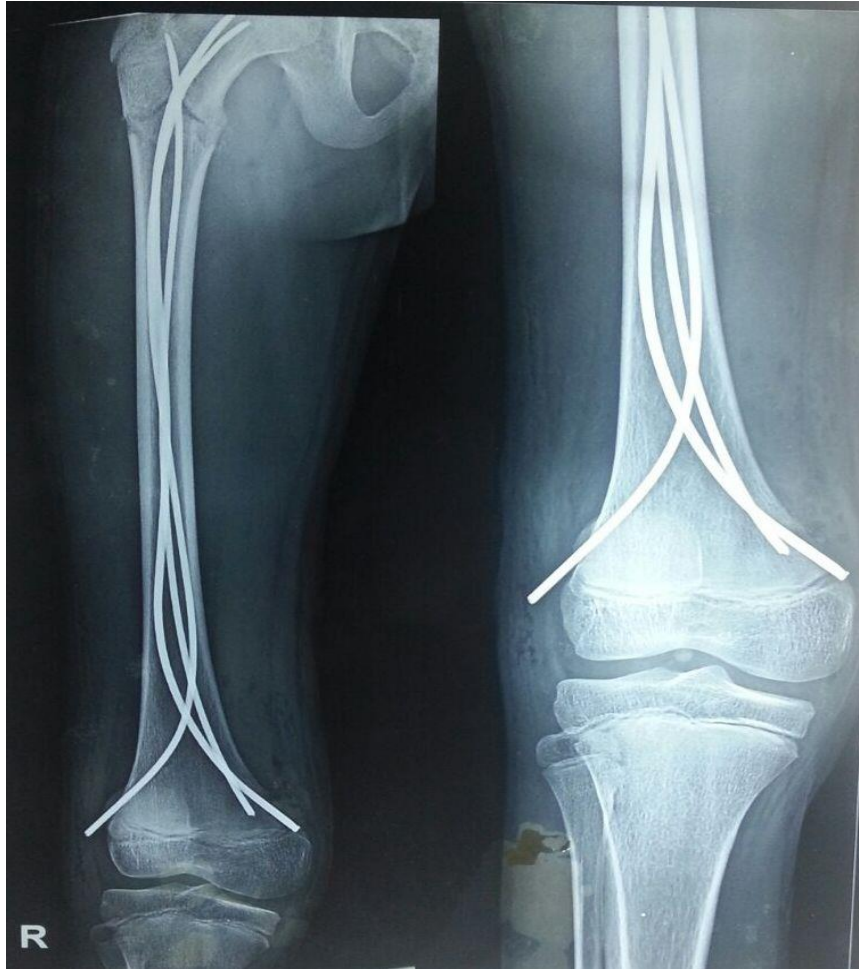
Immediate post-operative x-ray of right hip with thigh showing sub trochanteric femur fracture fixed with 3 TENS nails
